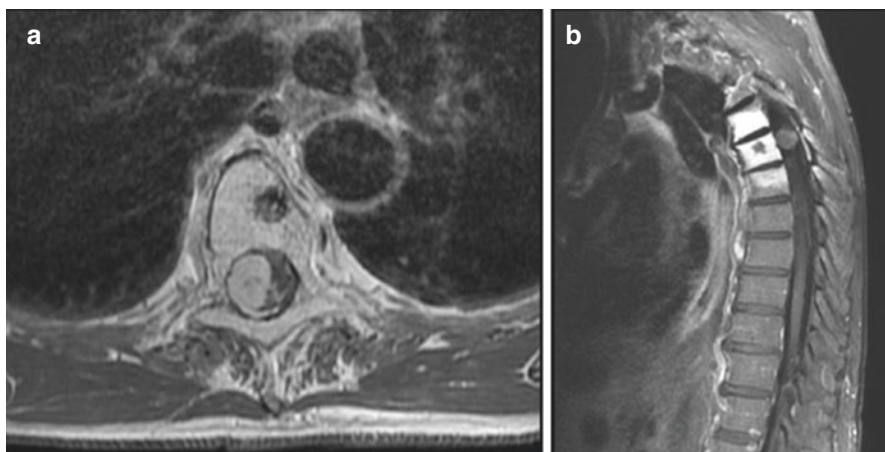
(a, b) T1-weighted axial and sagittal MRI with contrast showing a large enhancing intradural extramedullary mass compressing the spinal cord at its right aspect. Please note the tumor's lateral borders closely following the dura being suspicious of being intradural. Also note hyper-intense bodies secondary to previously radiated spine for known metastatic prostate cancer
